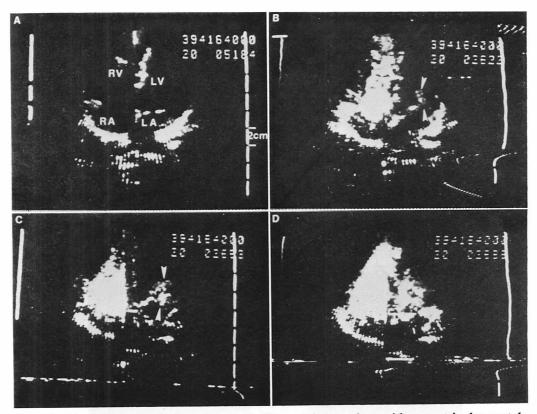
Two-dimensional contrast echocardiogram in a patient with a ventricular septal defect.
